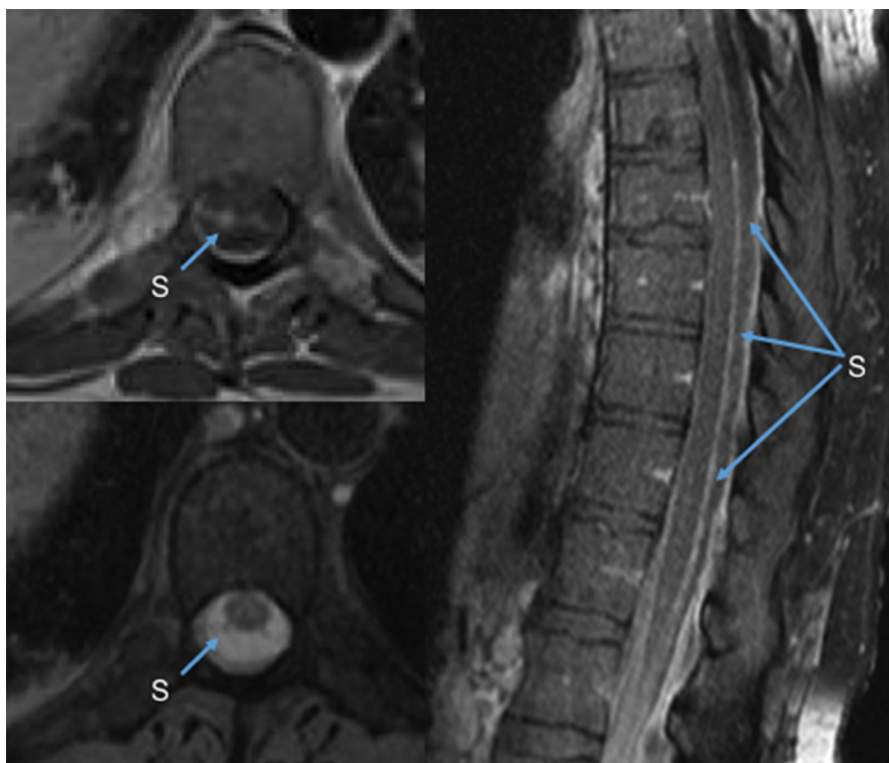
Subdural abscess (S) in the thoracic spine. T1-weighted post-contrast images reveal a peripherally enhancing subdural collection that mildly displaces the cord anteriorly, seen in axial (Top left) and sagittal (Right) views. There is curvilinear enhancement along the pial surface of the cord and along the posterior nerve roots. T2 axial imaging (Bottom left) also demonstrates that the fluid collection is subdural.
